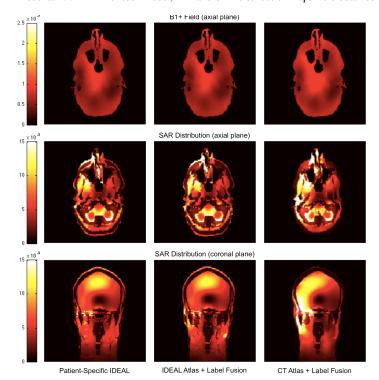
B1+ field (first row), and SAR distribution prediction in the axial (second row) and coronal planes (third row) using the patient-specific IDEAL acquisition (first column), the IDEAL multi-atlas and label-fusion approach (second column), and the CT multi-atlas and label-fusion approach (third column) for one of the subjects participating in this study.
